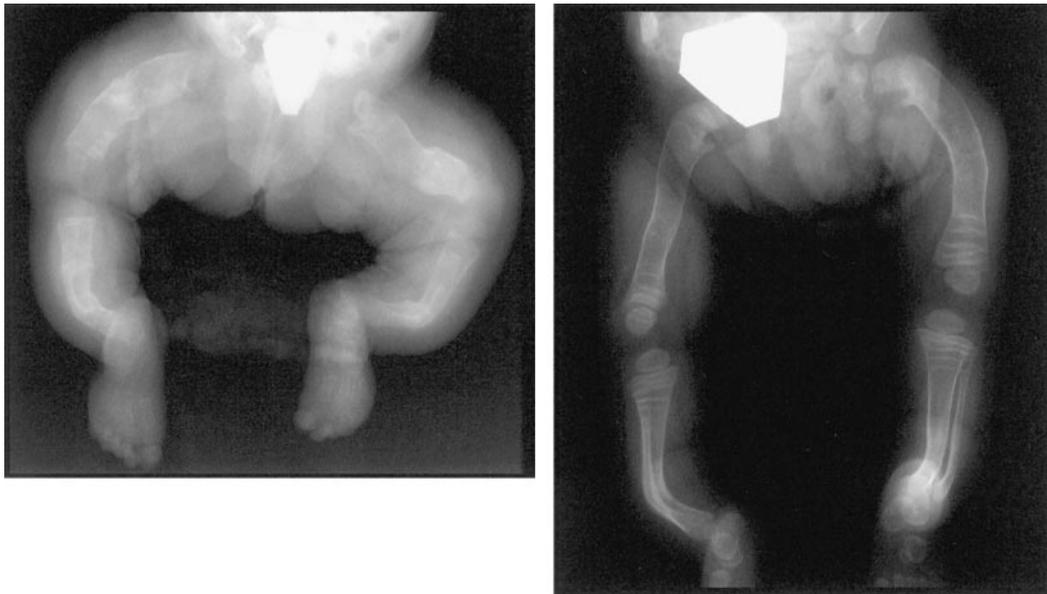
Radiographs of the lower limbs of patient 3 before (*left*) and after (*right*) 9.5 months of treatment with pamidronate.
